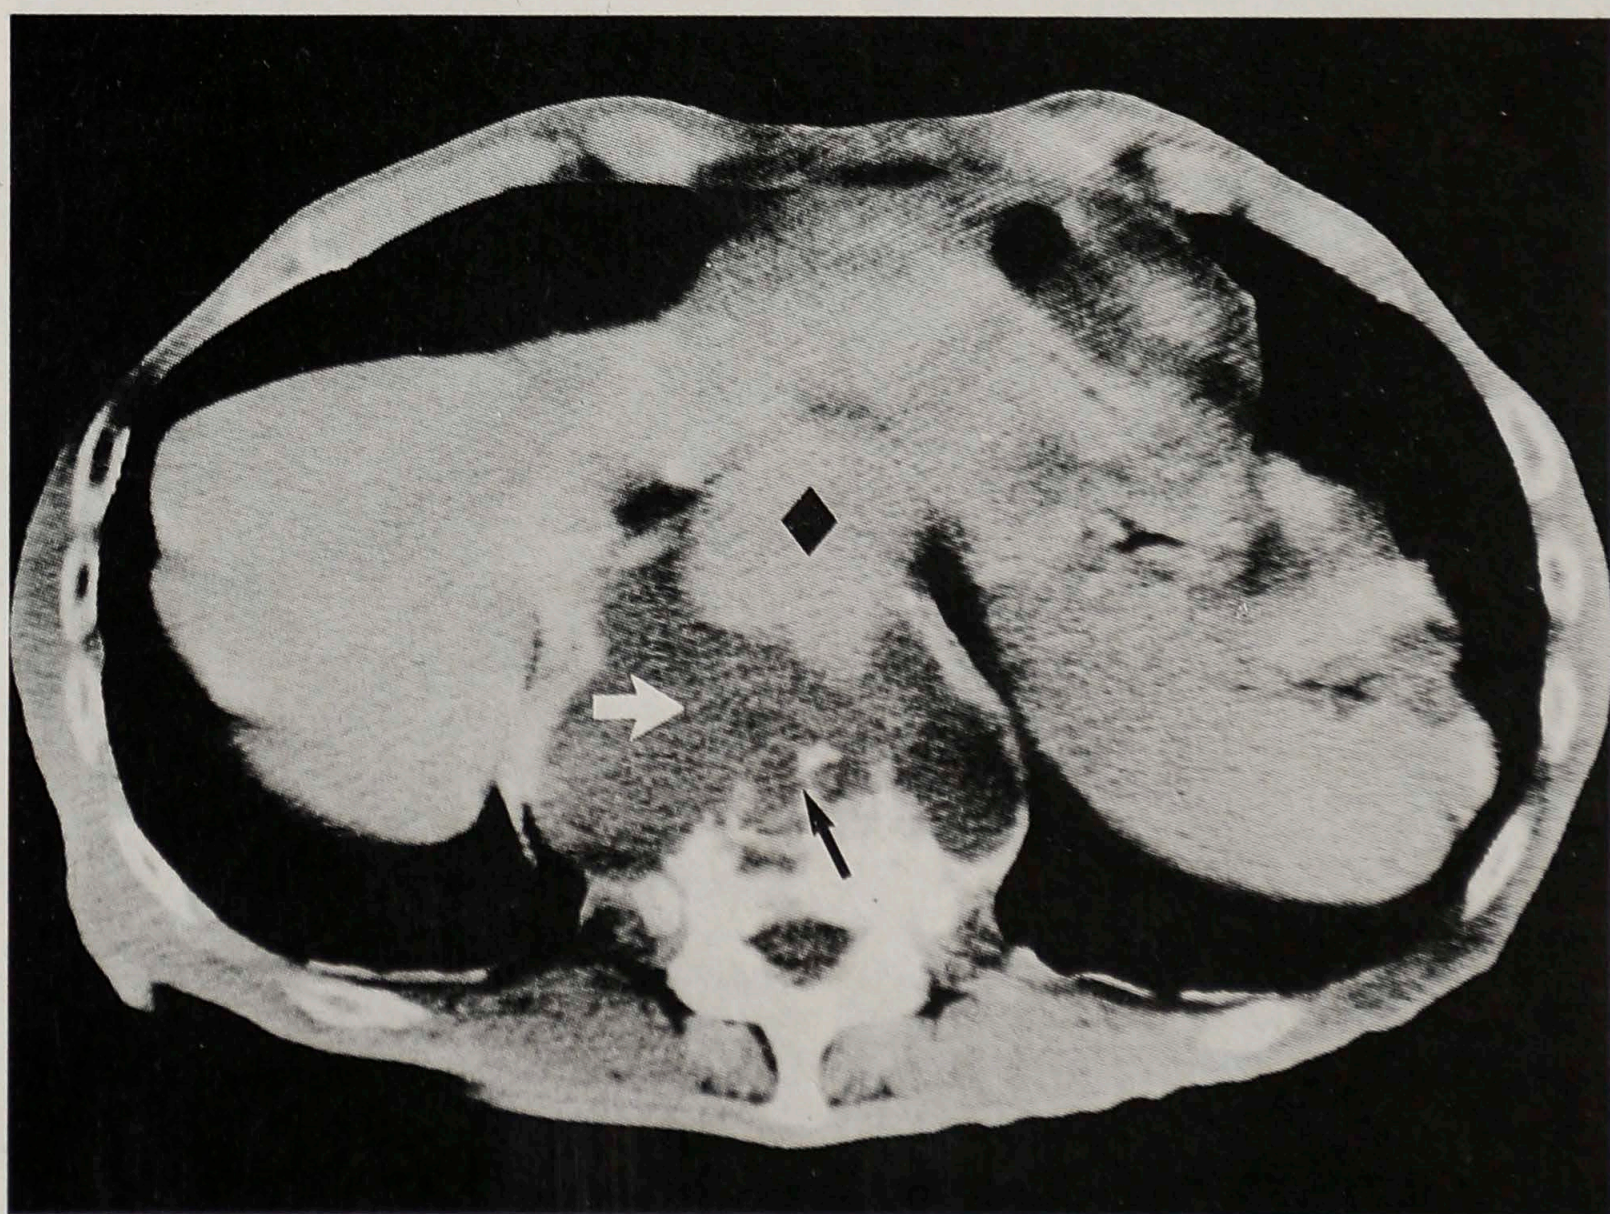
Case 3. (Left) Lateral x-ray film of thoracolumbar spine shows destruction and collapse of T11 and T12 vertebral bodies with obliteration of intervertebral spaces (arrows). (Right) CT scan demonstrates thoracic aortic aneurysm (diamond), large contained retrocrural hematoma (white arrow) and extensive vertebral body erosion (black arrow).
